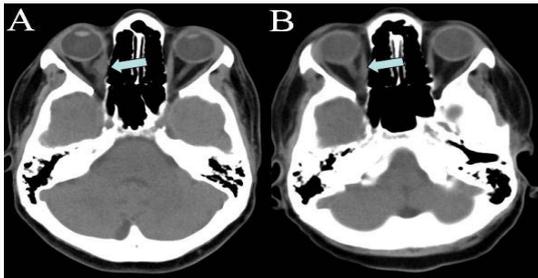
A) Initial axial CT scan images demonstrate an infiltrative solid nodule (arrow) located on the right orbit involving the medial rectus muscle. B) Axial CT scan images show further shrinkage of the lesion (arrow) after the chemotherapy.
